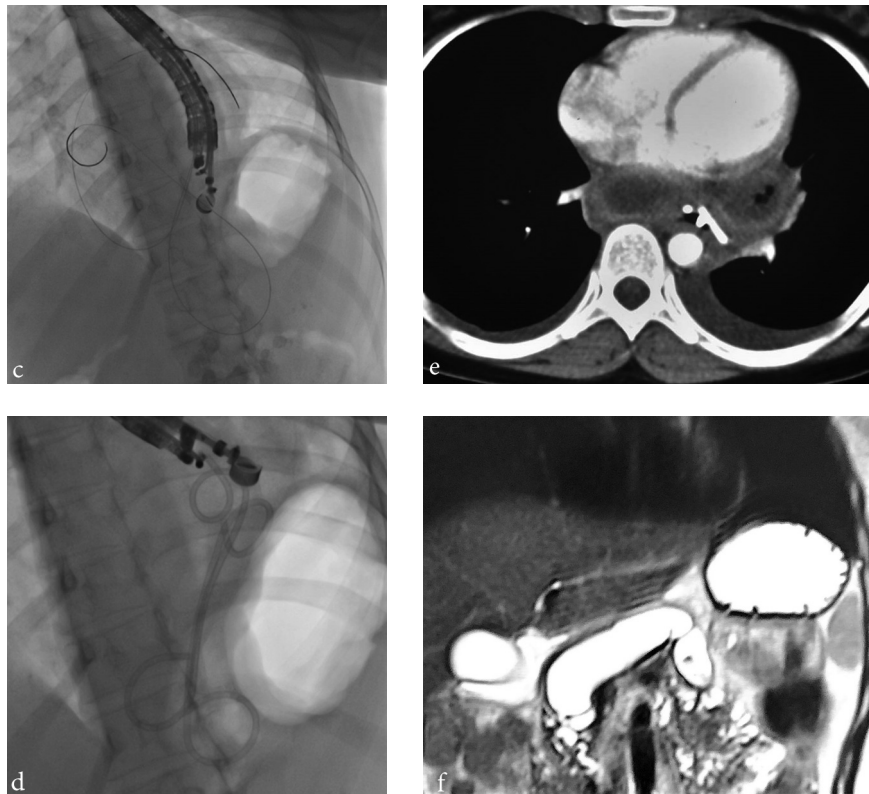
Two guide wires secured deep into the collection; d: Two 7Fr transmural stents placed; e: CT 3 days after drainage: marked reduction in size of cyst with transmural stents in situ. Mild bilateral pleural effusion is noted; f: MR abdomen and chest at 8 weeks: resolved pseudocyst with markedly dilated main pancreatic duct.
